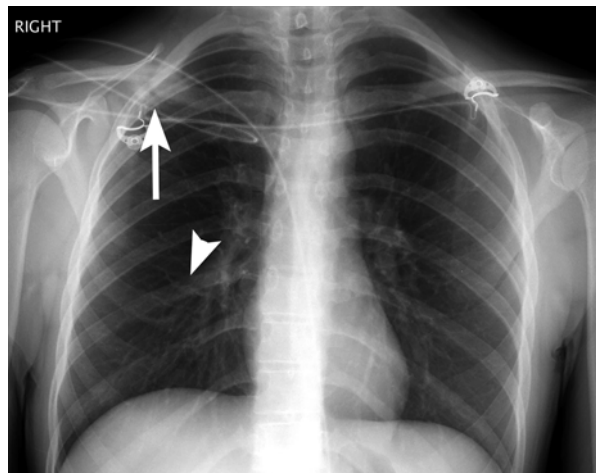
Chest radiograph shows an acute, non-displaced rib fracture (*arrowhead*) and a healed clavicle fracture from possible prior domestic abuse
